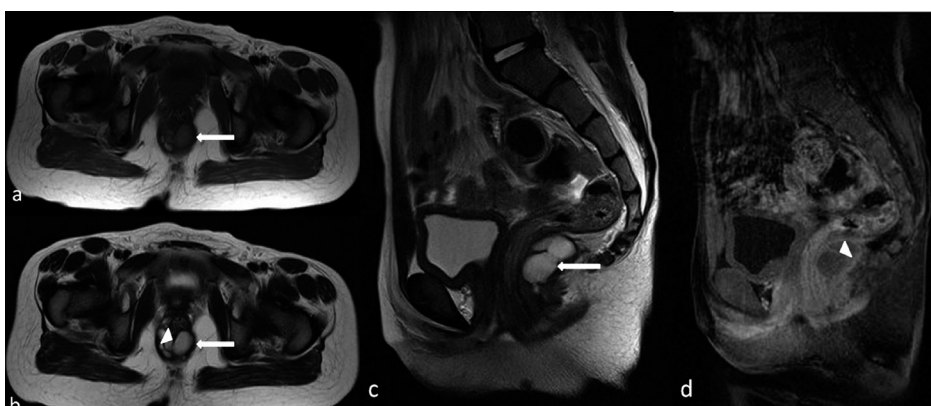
Tailgut cyst in 6-year-old female: (a) Axial T1-weighted MR image shows the well-defined, thin-walled cyst with intermediate signal intensity (arrow). (b) Axial T2-weighted MR image shows the well-defined cyst with homogeneous high signal intensity (arrow). Note the thick septum with low signal intensity (arrowhead). (c) Sagittal T2-weighted MR image shows the well-defined cyst with homogeneous high signal intensity (arrow) in retrorectal space. Rectum is anteriorly displaced. (d) Contrast-enhanced sagittal T1-weighted MR image shows enhanced thick septa (arrowhead).
